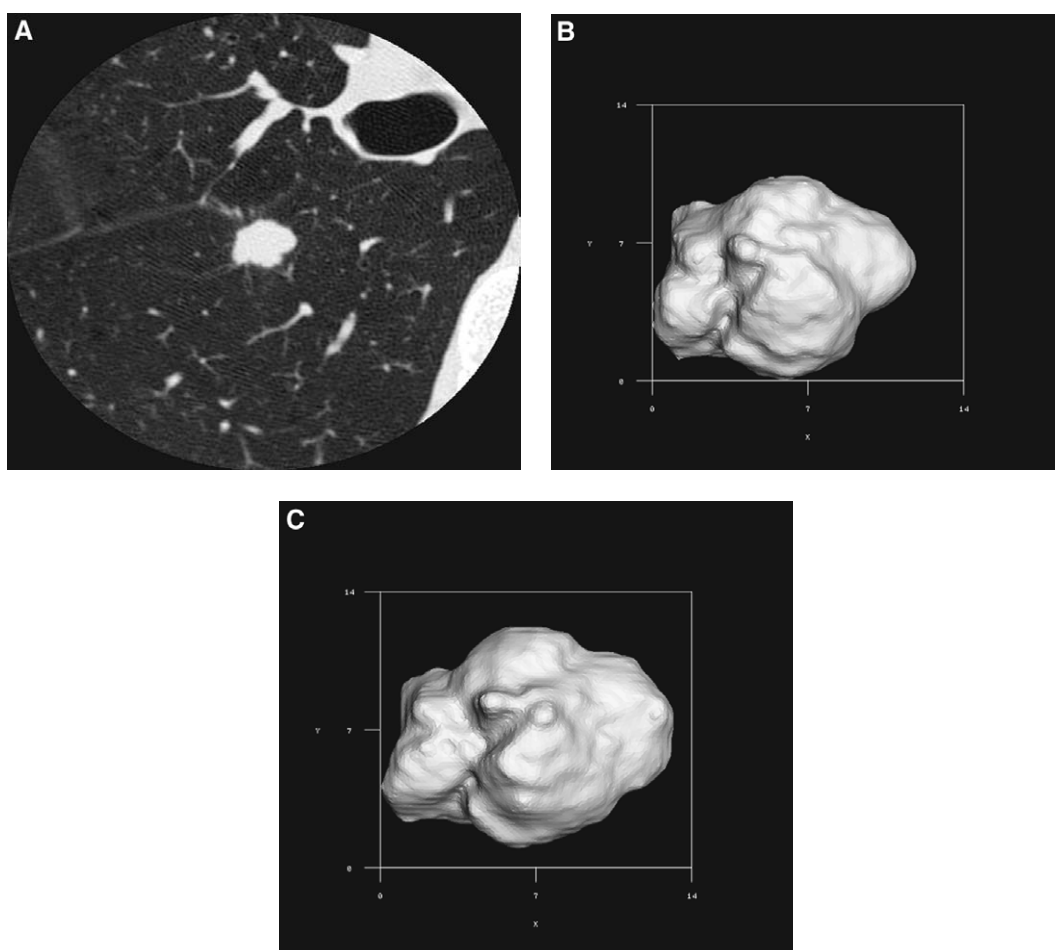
(A) A 10 mm nodule was identified on CT. (B) Three-dimensional volumetric reconstruction was performed on the initial CT data. (C) One month later. The nodule has grown during this short interval. An increase in volume was 22% has been determined by use of an image processing technique, corresponding to a malignant growth rate.
